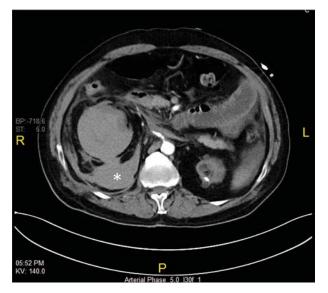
Abdominal contrast-enhanced computed tomography scan showing retroperitoneal hematoma on the right side (white asterisk) with no active bleeding in the arterial phase.
